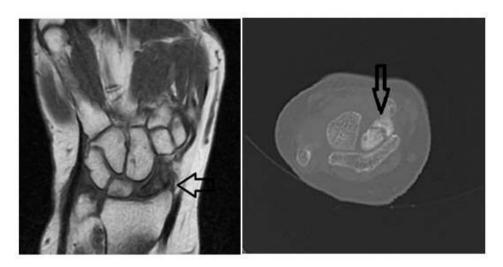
Magnetic resonance imaging of the right hand and wrist, and avascular necrosis of the scaphoid bone.
